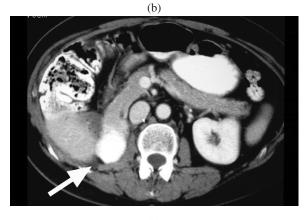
Metastatic fibrosarcoma. (a) Coronal PET-FDG image shows peritoneal metastatic nodule (arrow). (b) Axial contrast-enhanced CT shows this metastatic nodule (arrow), which was not prospectively identified as it was thought to be part of the left lobe of the liver.
